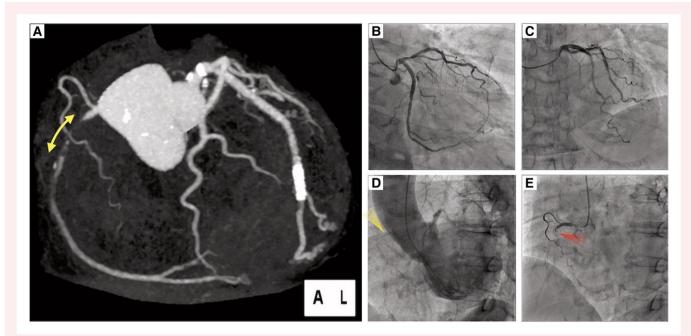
Previous procedure information. (A) Cardiac computed tomography (CT) suggesting a total occlusion of 10 mm in the right coronary artery (RCA) #2 (yellow arrow). (B) Left coronary angiography (RAO 30°/CAU 30°). (C) Left coronary angiography (CRA 30°). (D) RCA is confirmed using left ventricular angiography (yellow arrow). (E) RCA angiography was successfully performed using a hand-made curved JR5.0. The total occluded lesion was confirmed (red arrow).
